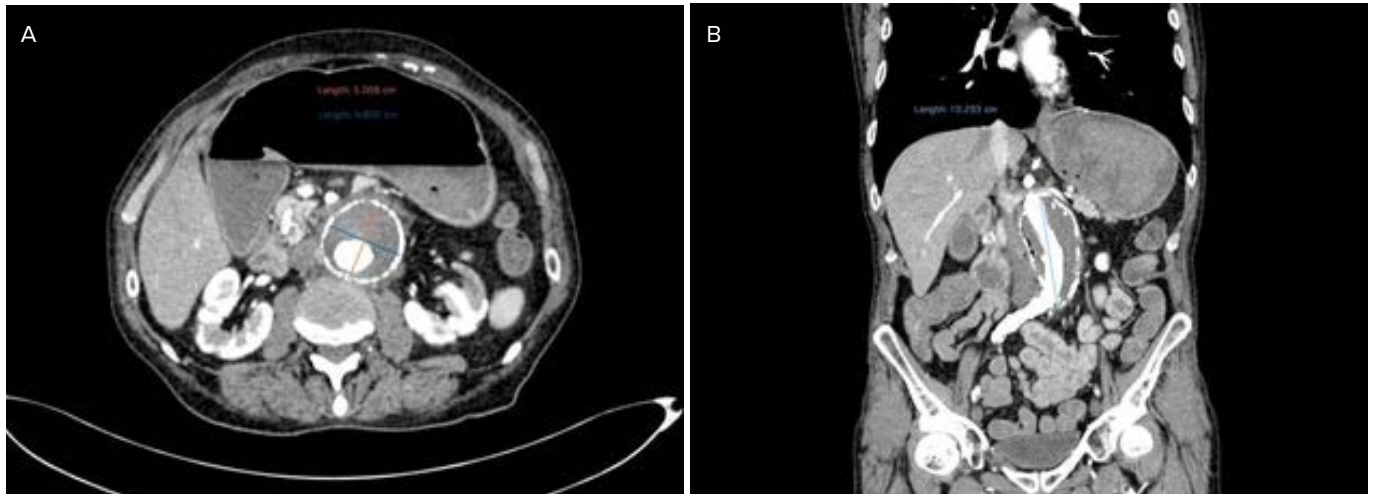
CT angiography: A – axial section: infrarenal aortic abdominal aneurysm AP and LL diameter; B – coronal section, aortic abdominal aneurysm CC diameter
